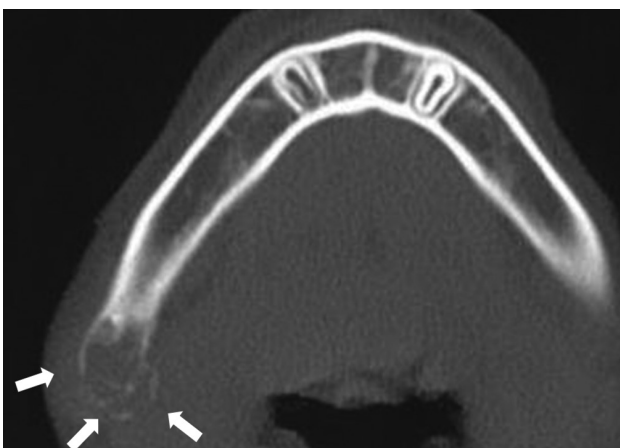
Computed tomography image obtained in the axial plane. A bone-like spicule was observed around the cortical bone defect with an unclear border (arrows).
